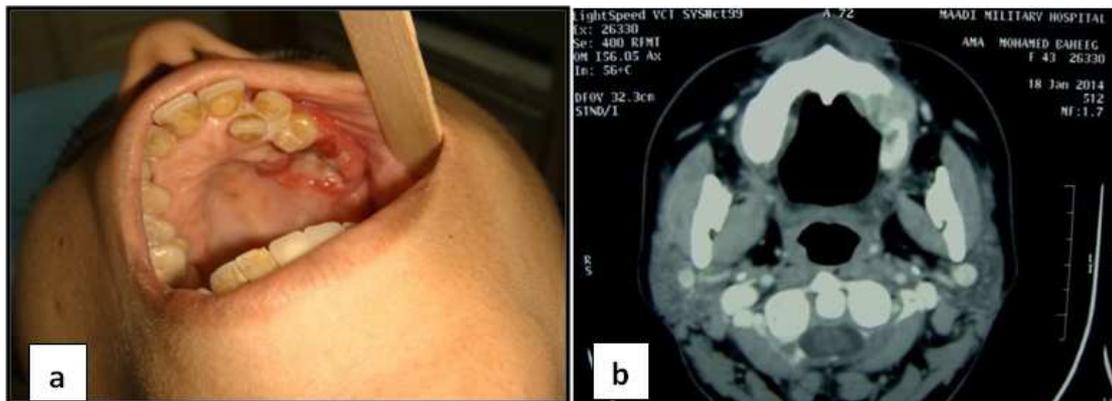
(a) Alveolar OSCC of the left posterior maxillary ridge extending to the palate. (b) Axial CT revealing the tumor implicating the left posterior maxillary ridge with buccolingual invasion and bone destruction. The ipsilateral cervical lymphadenopathy is inflammatory (non-specific).
